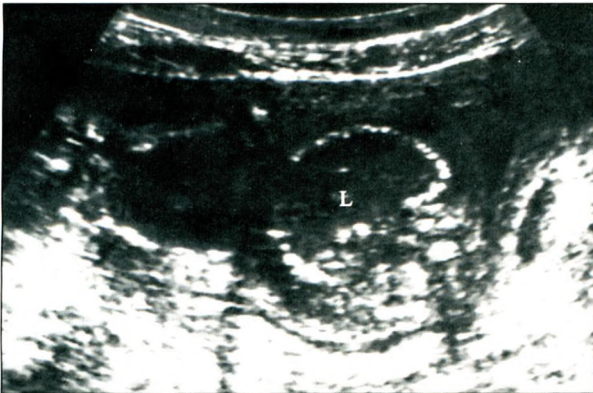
(d): Sagittal sonogram (spine down) demonstrating diffuse perihepatic calcifications (L: Liver)
